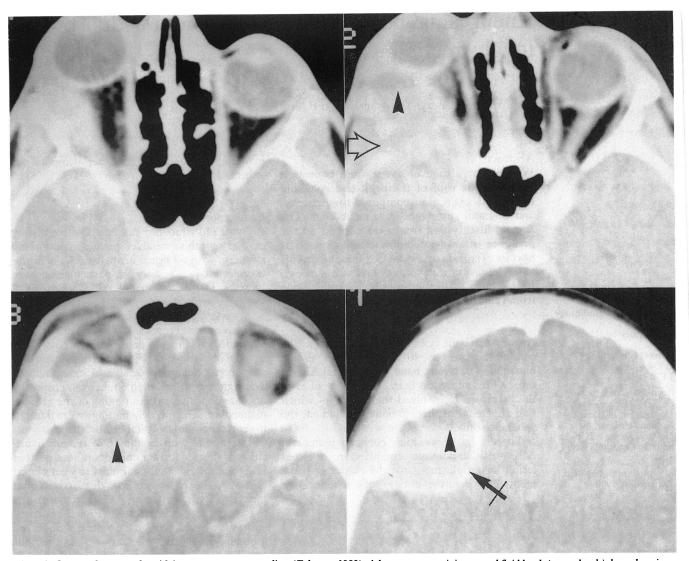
Computed tomography with intravenous contrast medium (February 1989). A large mass containing several fluid levels (arrow heads) due to layering of blood expands into the orbit and the anterior and middle cranial fossae, eroding the bone laterally (open arrow) towards the temporal fossa. It appears to have a capsule (crossed arrow).
